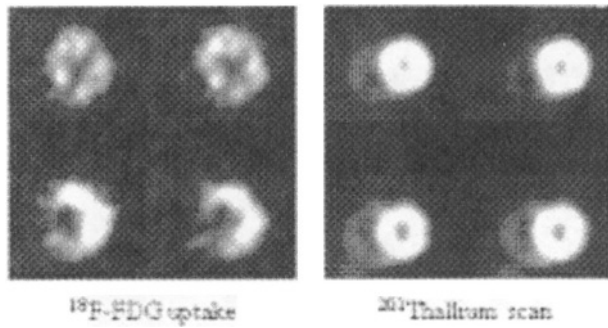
Pathological ^{18}F -FDG uptake but normal ^{201}Tl myocardial perfusion scans in a symptomatic patient with systemic lupus erythematosus
